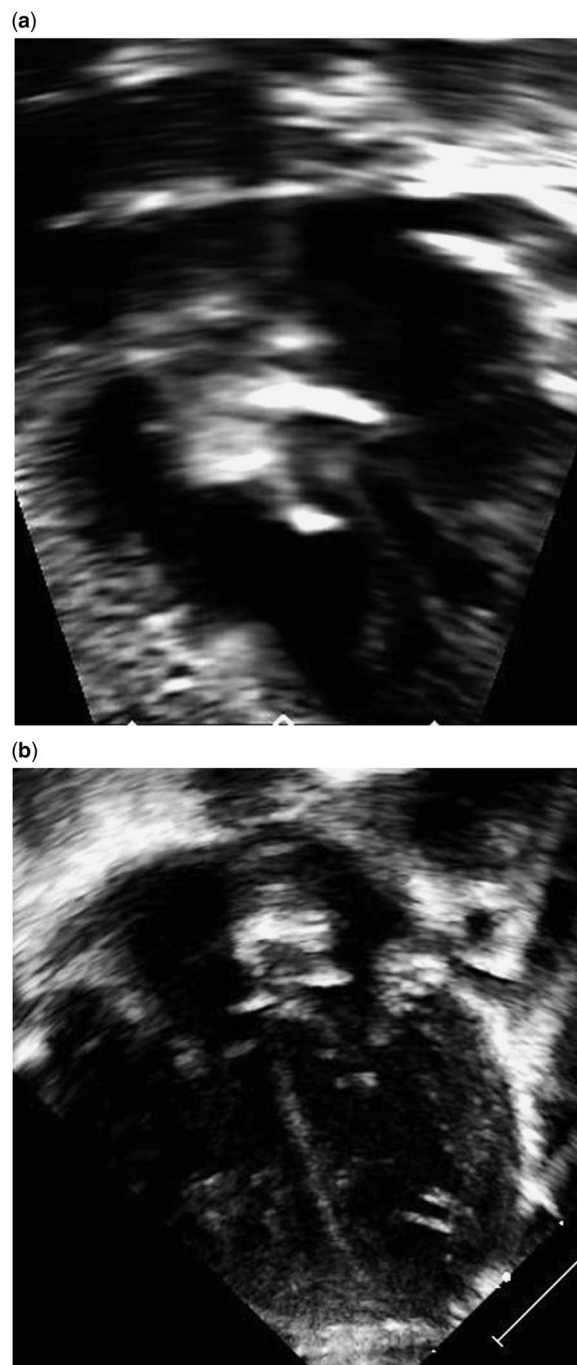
(a) Subcostal and (b) apical four-chamber views in patient 2 after deployment of the HELEX Septal Occluder. Both views show the device to be well positioned.
